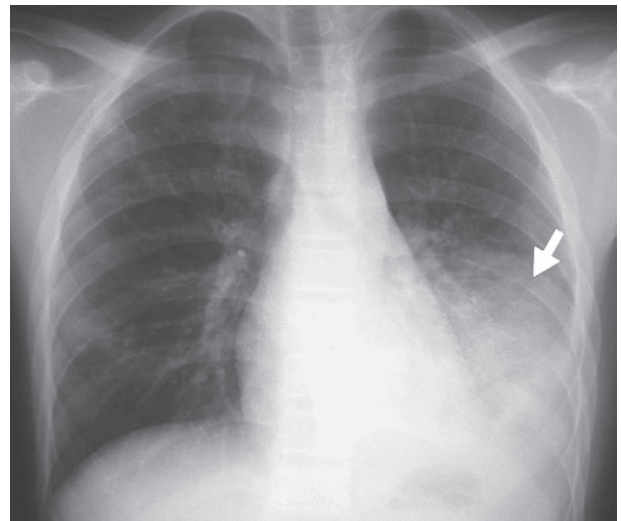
A 12 year-old boy presented with an approximately 1 week history of productive cough and rhinorrhea. Initial chest radiograph shows lobar consolidation (arrow) in the left lower lung zone with left pleural effusion.
